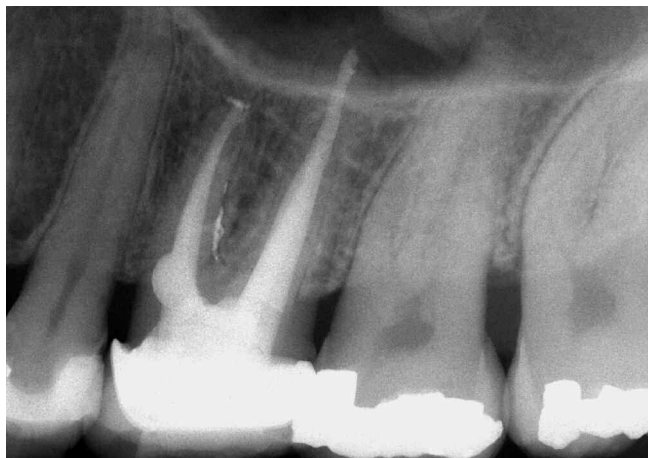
An off-angled radiograph reveals a well-packed resorptive defect, a furcal canal and the provisionalized PFM crown.
